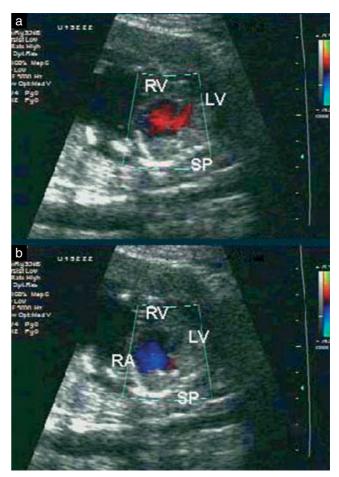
Color Doppler ultrasound images showing (a) ventricular filling (red) during diastole and (b) reversal of flow (blue) in the right atrium (RA) during systole. LV, left ventricle; RV, right ventricle; SP, spine.
